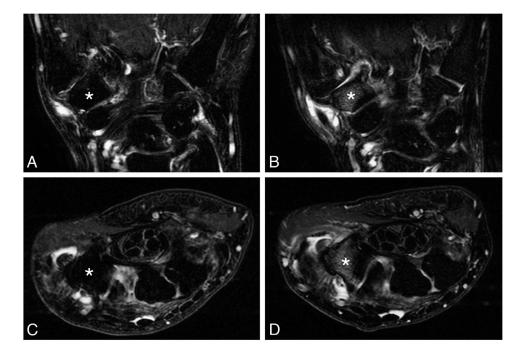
Coronal (A and B) and axial (C and D) fat saturated T2-weighted fast spin-echo magnetic resonance imaging from a study participant showing decrease in bone marrow lesions in the trapezium bone (asterisks) at a two-year follow-up visit (A and C) compared to baseline (B and D).
